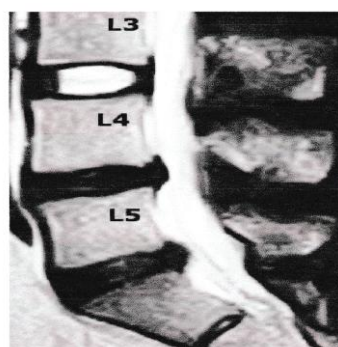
Showing the MRI appearance of degenerated disc.
